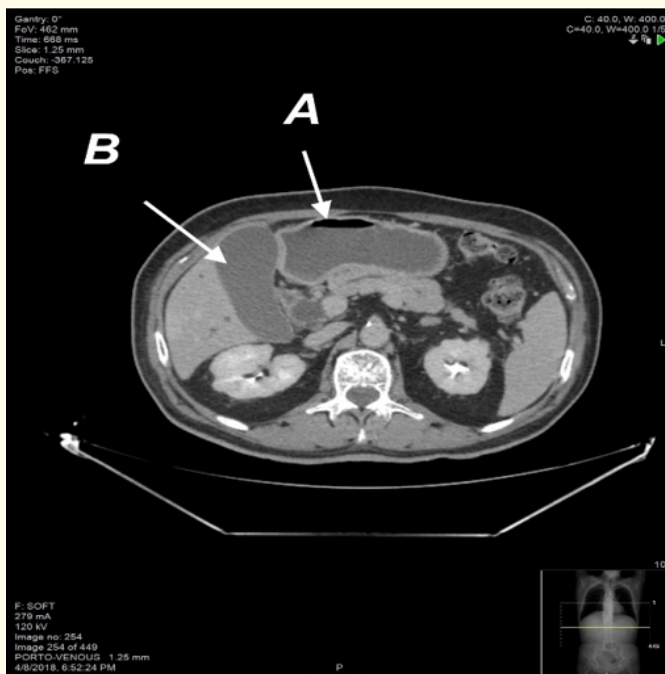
The emergency CT of the abdomen and pelvis showing severely dilated stomach (A) and dilated gallbladder (B).
